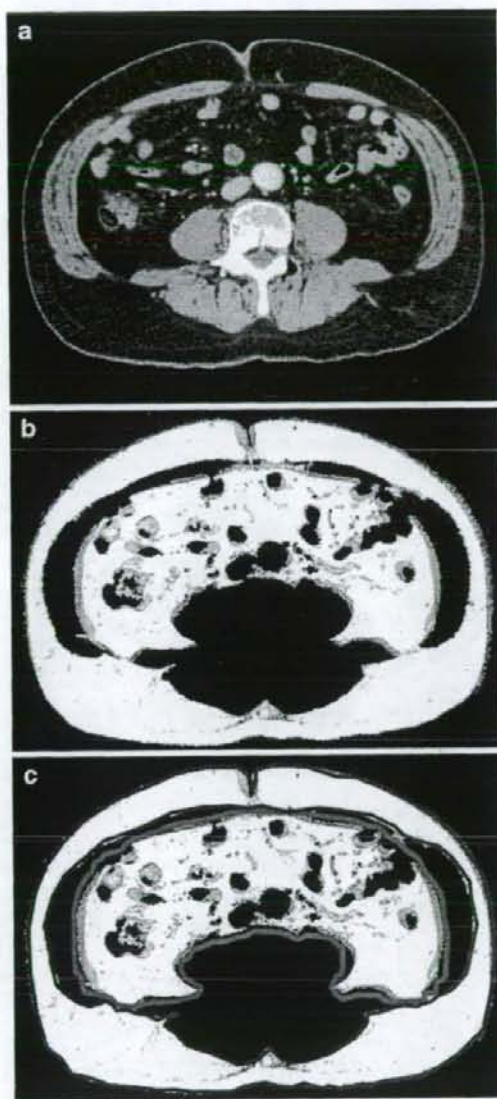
Quantification of visceral fat area (VFA) on CT scan. A. Original CT scan image at the level of the umbilicus. B. Alteration of the window width for the detection of adipose tissue. C. The visceral fat region is determined by outlining the intra-abdominal component (red line), and the remaining as the subcutaneous fat region (between the 2 blue lines).
